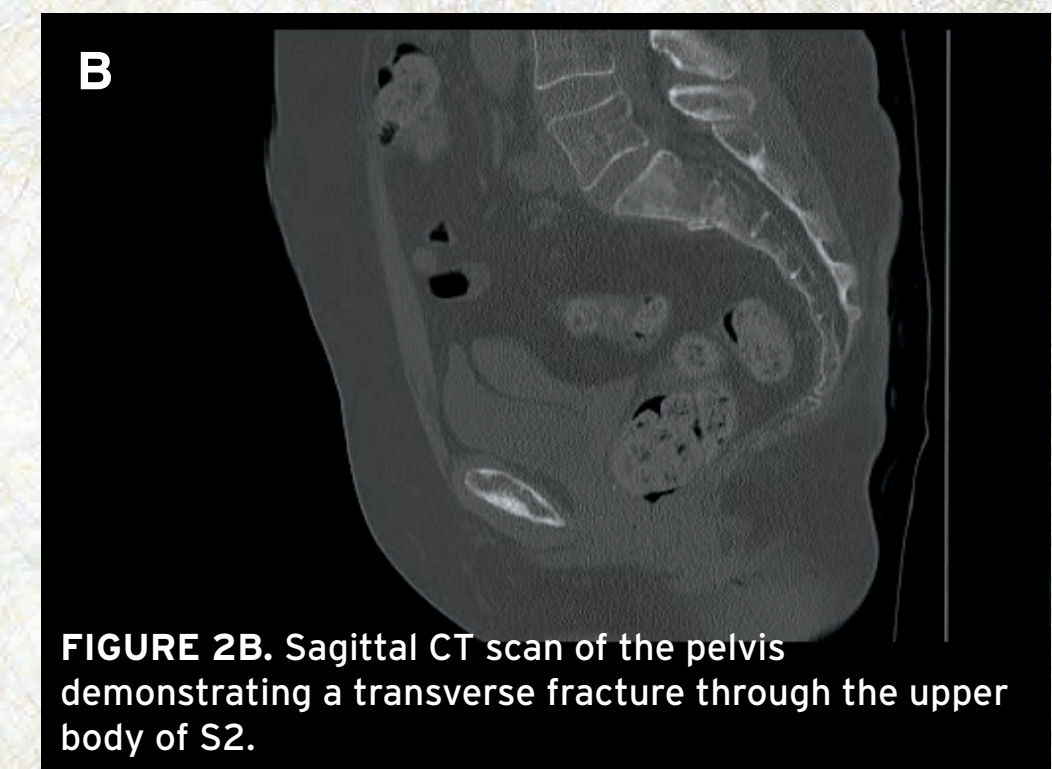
Sagittal CT scan of the pelvis demonstrating a transverse fracture through the upper body of S2.
